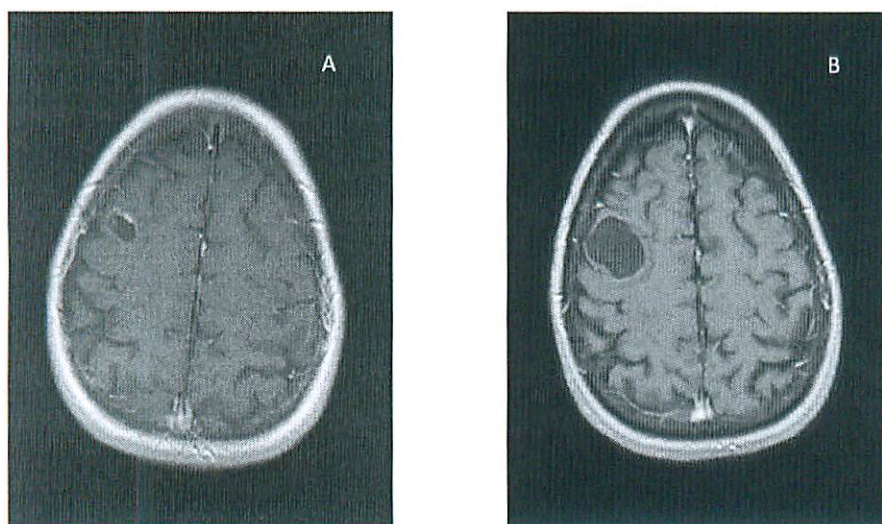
Axial MR images with gadolinium showing a right frontal lobe lesion. A) Axial T1 post gadolinium sequence showing intra-axial R. frontal lobe cystic lesion with minimal peripheral enhancement, measuring 1.1 cm x 1.1 cm. No mass affect no midline shift. Evaluated on August of 2003. B) Axial T1 post gadolinium sequence demonstrating a hypointense intraaxial right frontal lobe mass with minimal peripheral enhancement, measuring 2.5 cm x 1.8 cm, enlarged in size. Evaluated June, 2010.
